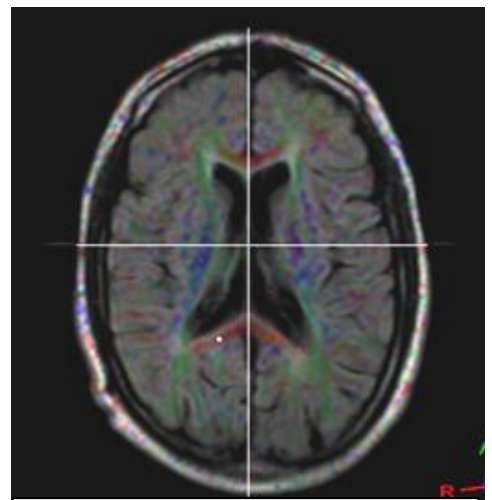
Case (1) fused FLAIR/DTI Axial image
